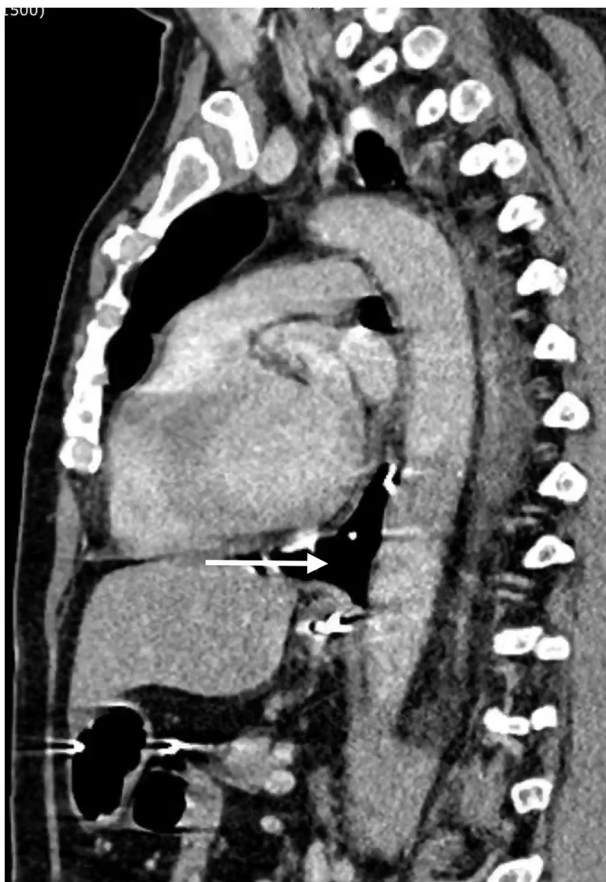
Follow-up computed tomography scan showing a mediastinal abscess with gas shadows (arrow), indicating ongoing mediastinal infection requiring surgical intervention.
